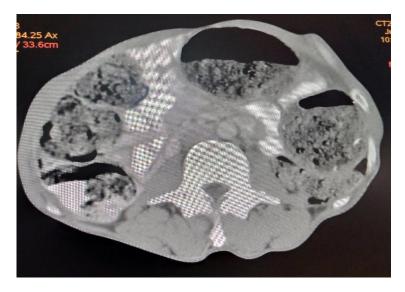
Computed tomogram of the abdomen, axial plane showing multiple dilated bowel loops with debris in the dependent portion and air superiorly.
